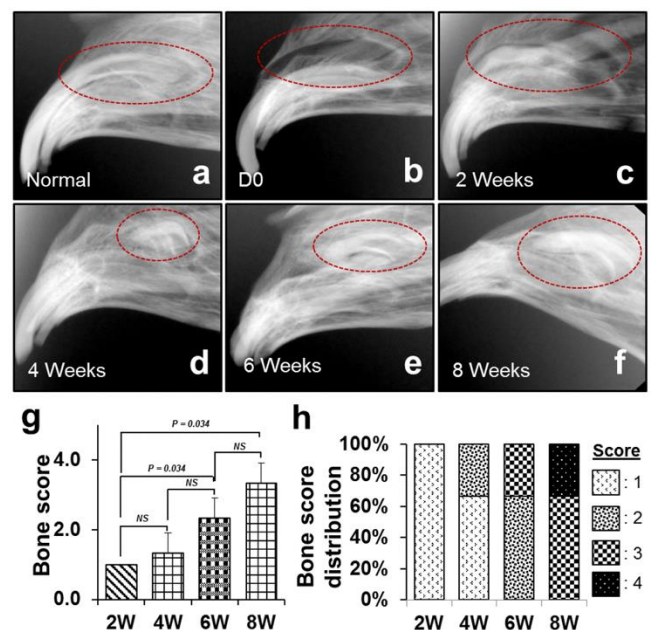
Alveolar bone healing in defect model examined by radiograph
